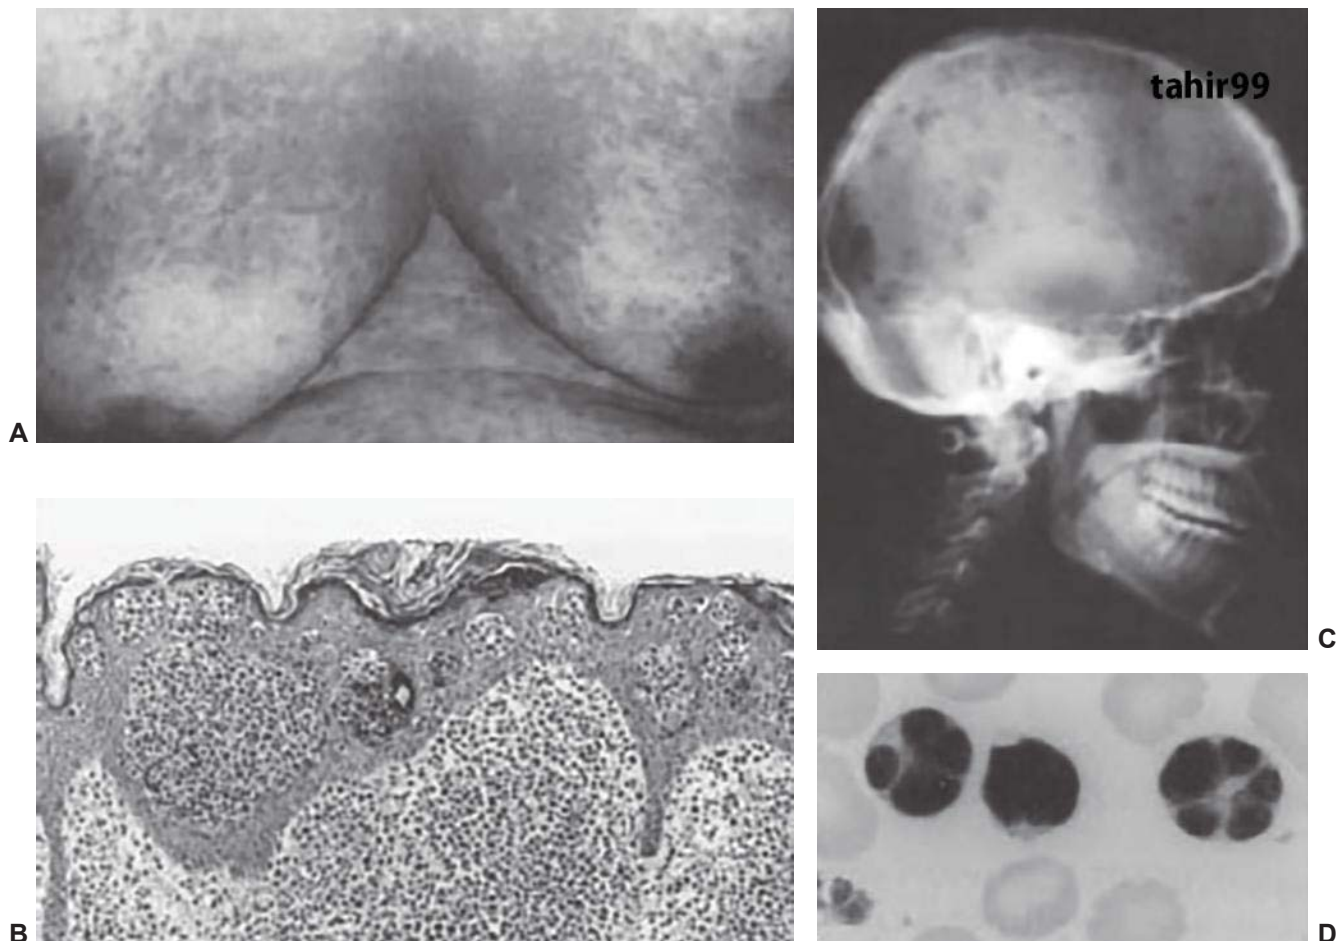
Clinical manifestation of adult T-cell leukemia/lymphoma. (A–B) Infiltration of malignant T lymphocytes into the skin. (C) Lytic bone lesions seen on lateral skull x-ray. (D) "Flower cells" in the blood.
